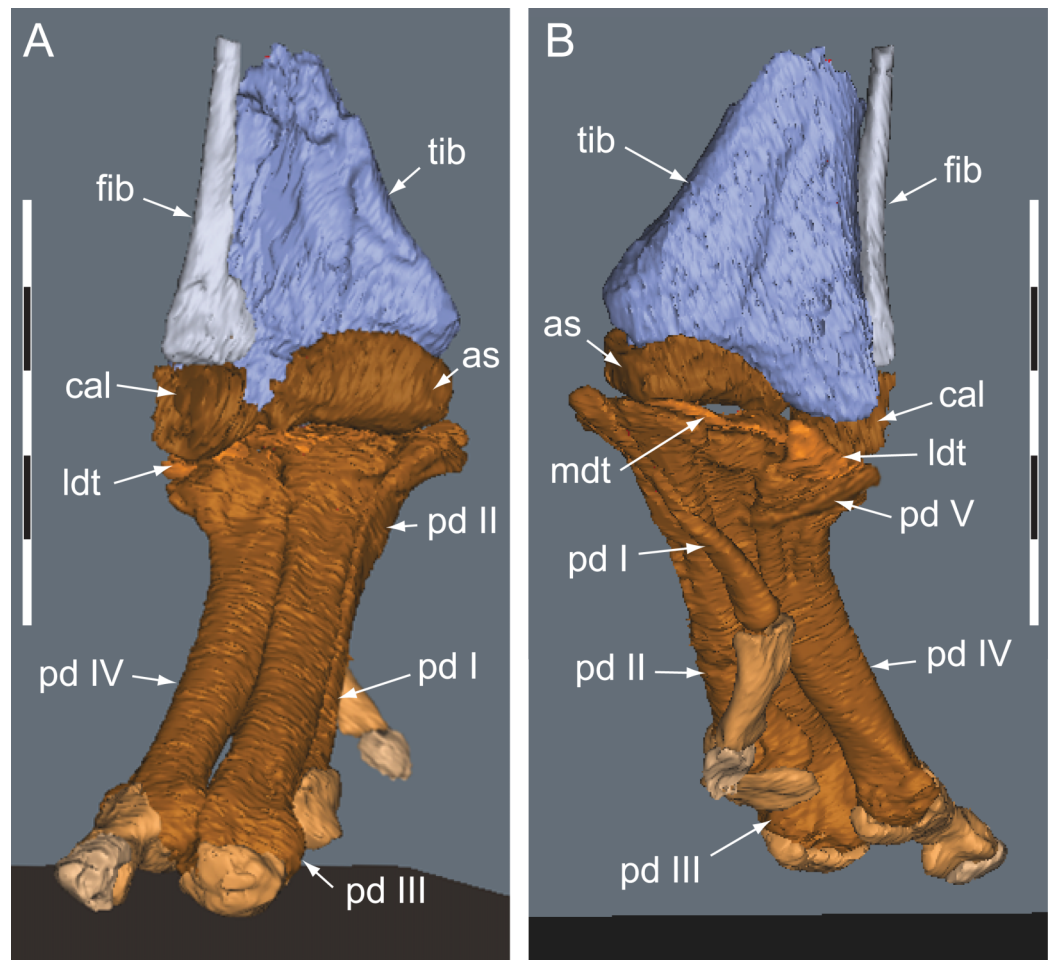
Diluvicursor pickeringi* gen. et sp. nov. holotype (NMV P221080), CT restoration of the right distal crus, tarsus and pes. A–B: (A) anterior/dorsal; and (B) plantar views. Abbreviations: as, astragalus; cal, calcaneum; fib, fibula; ldt, lateral distal tarsal; mdt, medial distal tarsal; pd, pedal digit number; tib, tibia. Scale bars equal 50 mm. [Full-size !\[\]\(5fd6ef84f97f42d7f8b34275f1b65312_img.jpg\) DOI: 10.7717/peerj.4113/fig-20](https://doi.org/10.7717/peerj.4113/fig-20)
